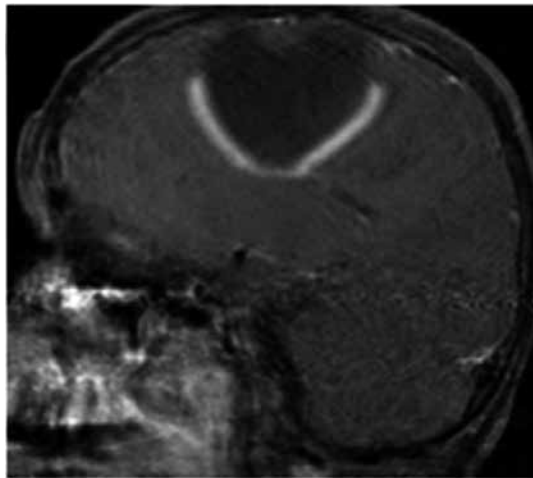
A case of TDL demonstrating incomplete rim enhancement on sagittal T1-weighted images after intravenous contrast administration.
